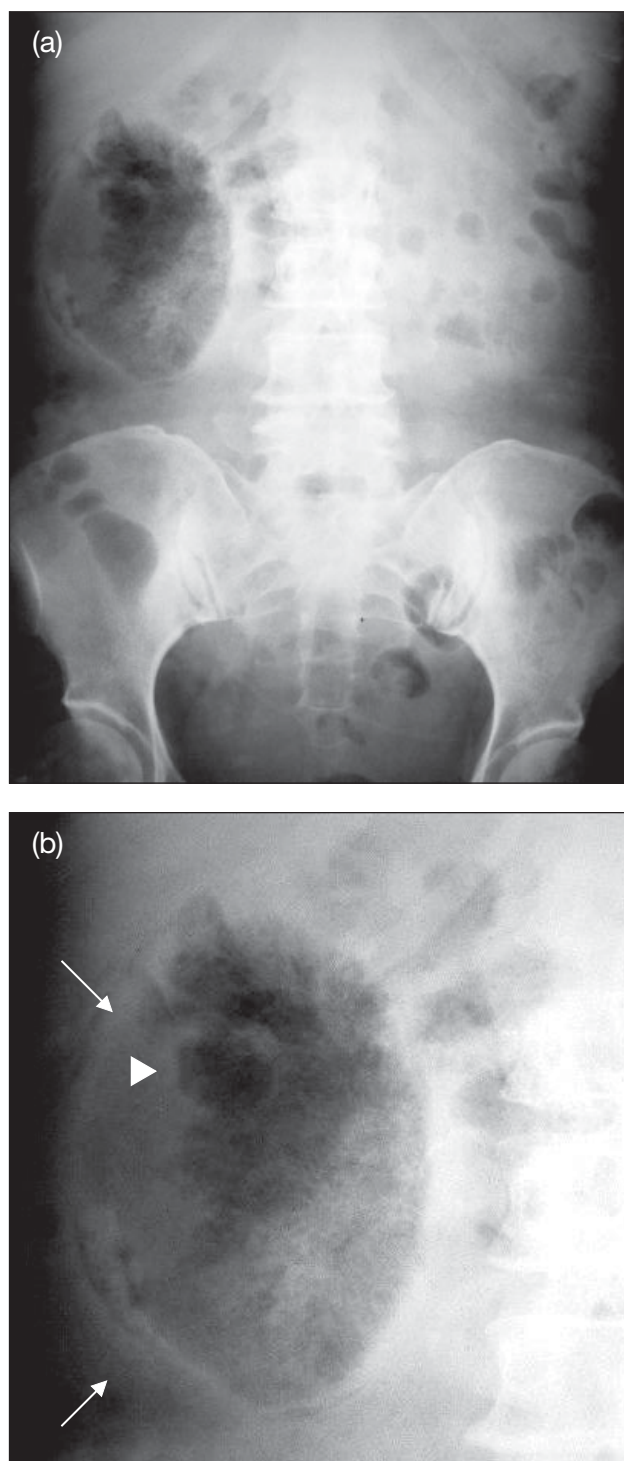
Radiographs of the patient
